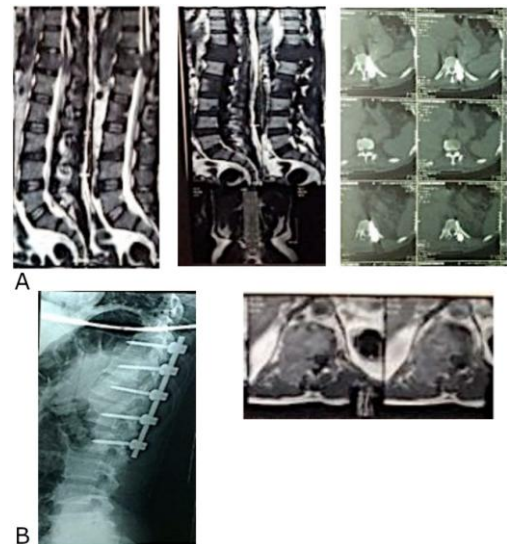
A) Preoperative Sagittal T1WI, T2WI and Axial T1WI; B) Postoperative Plain X-ray and Axial CT scan after fixation
